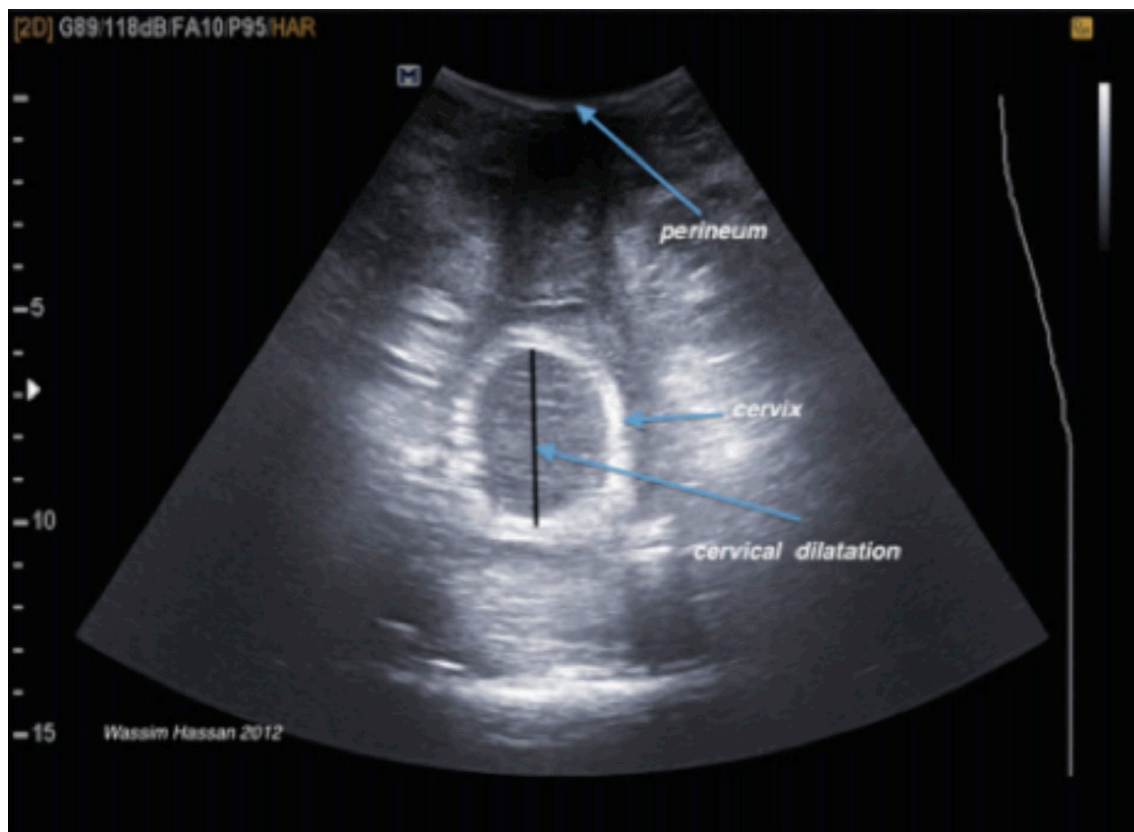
Cervical dilatation assessed by 2D transperineal ultrasound during labour.²⁰ The cervical dilatation is clearly visible at the centre with the vaginal wall hypoechoic laterally to the cervix. At the top of the picture is the perineum where the transperineal probe is placed.
